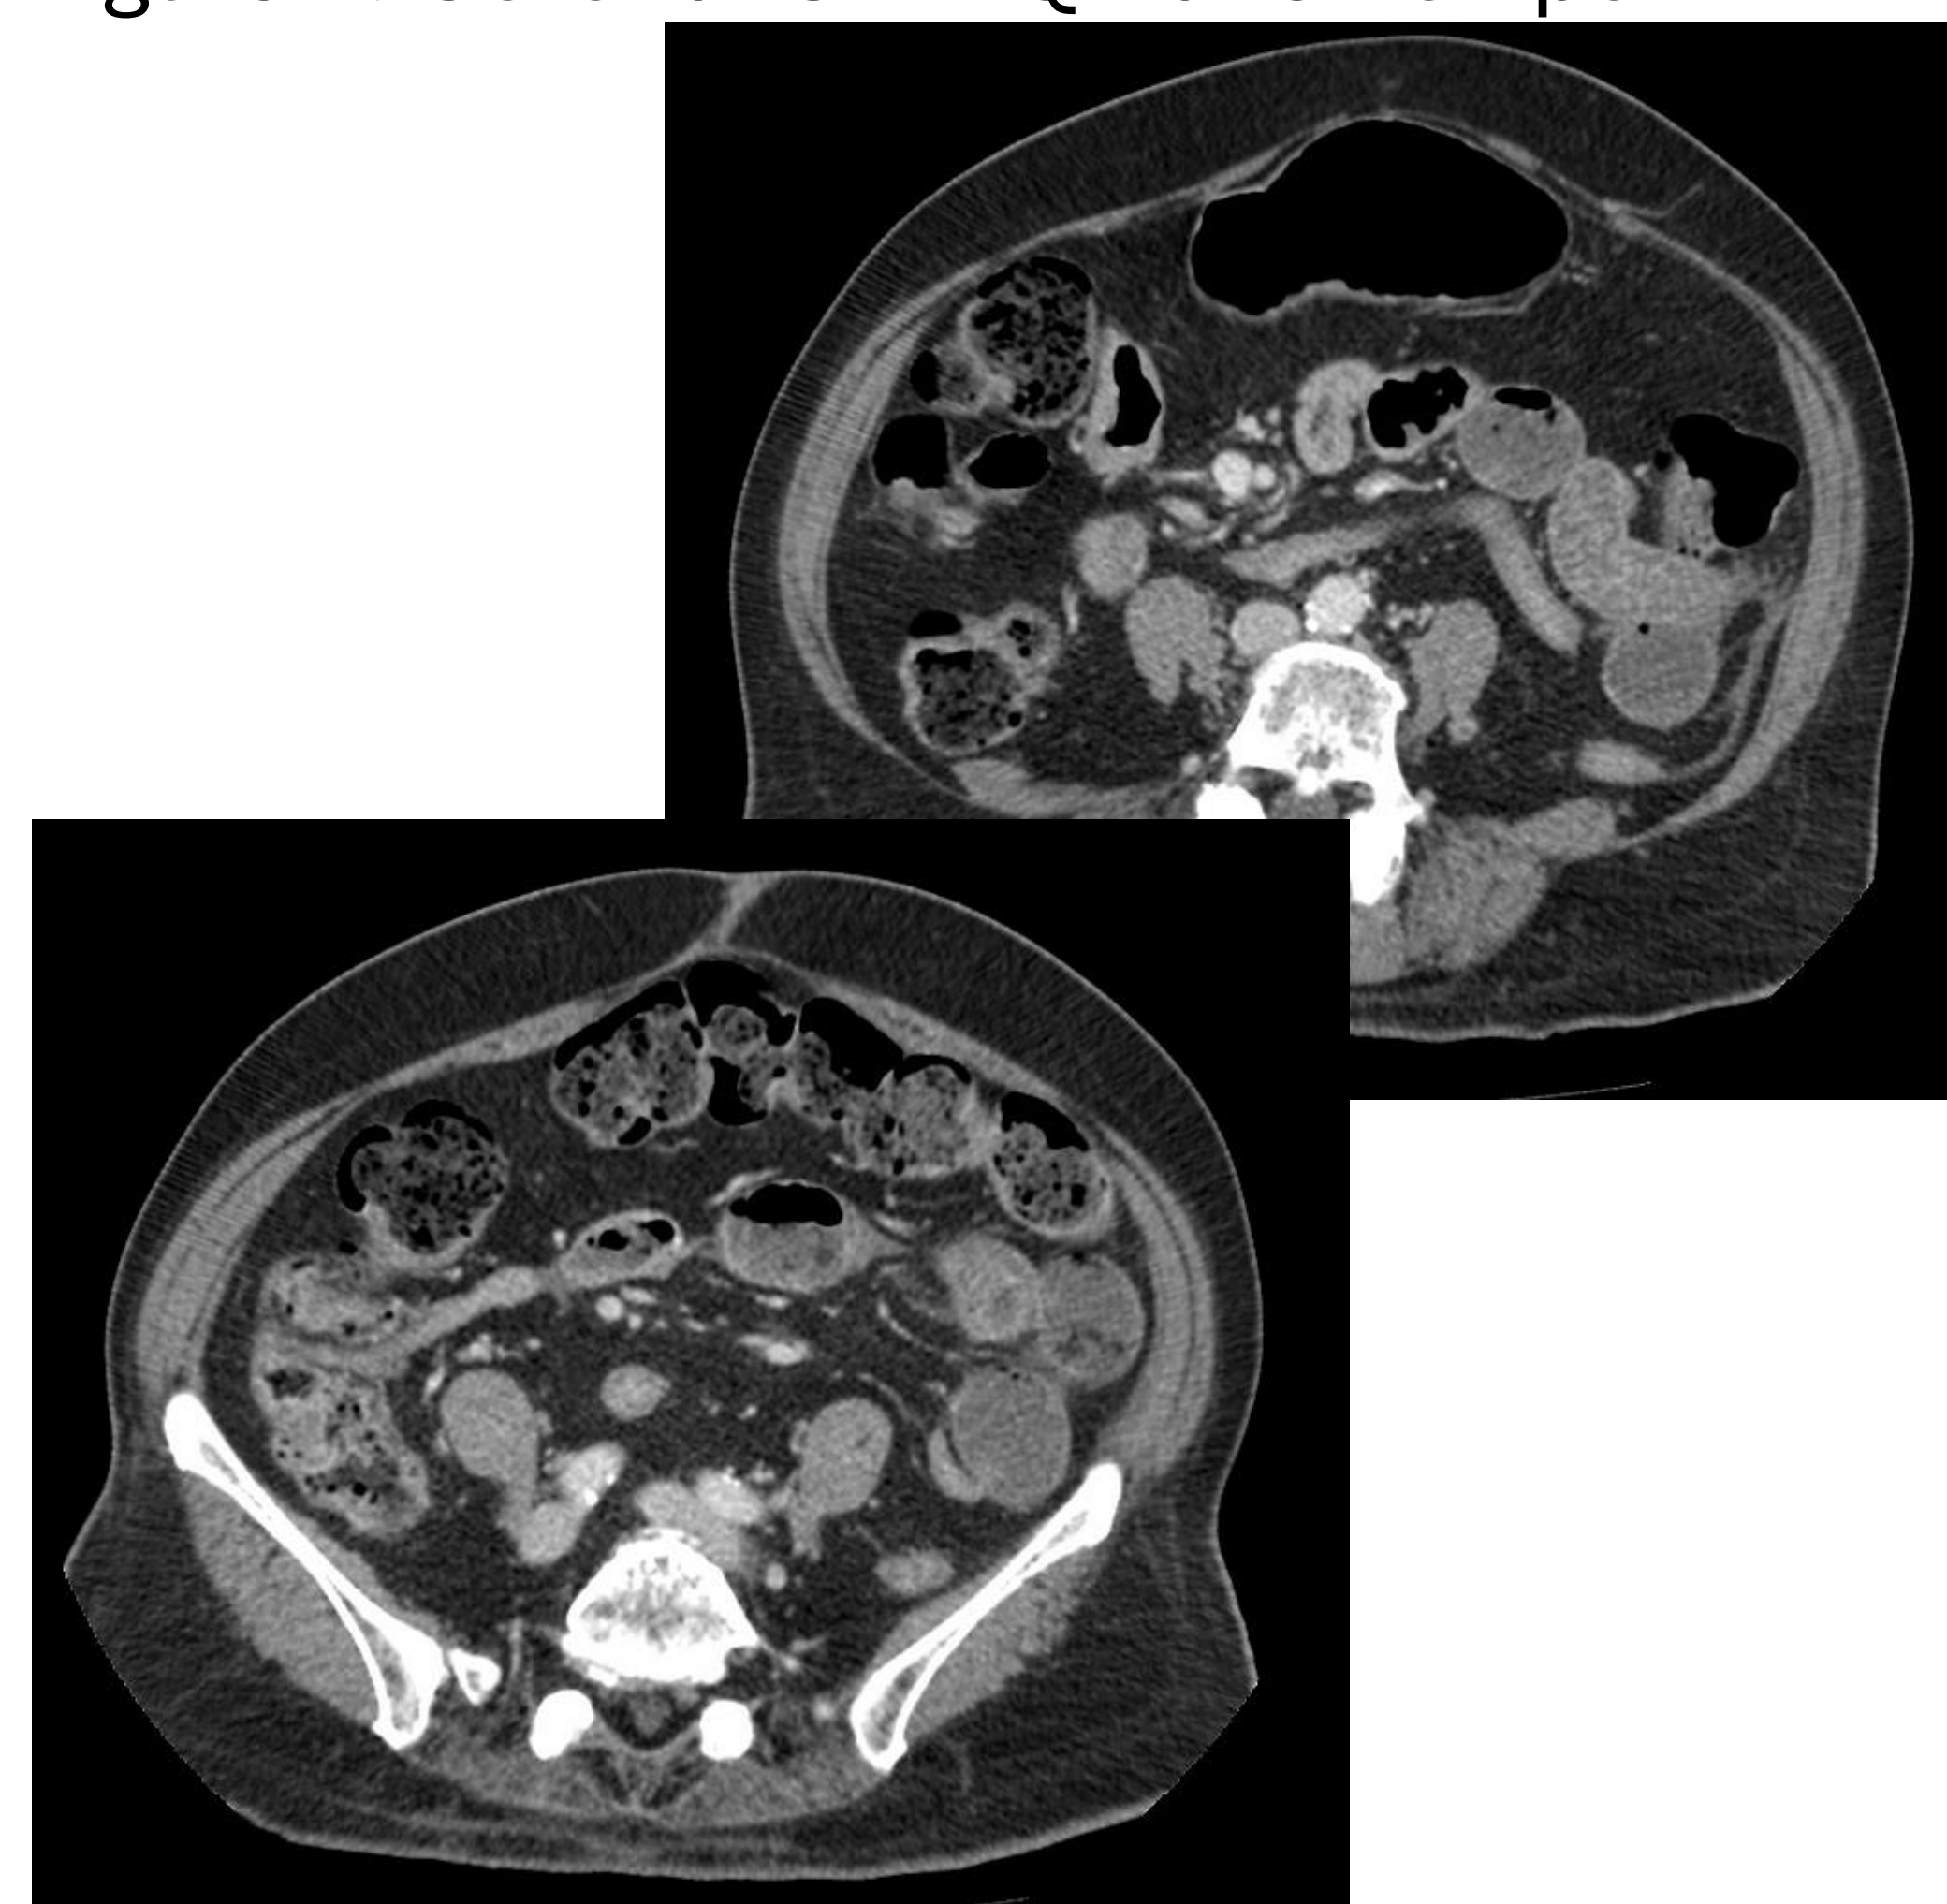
Axial CT LLQ transition point
